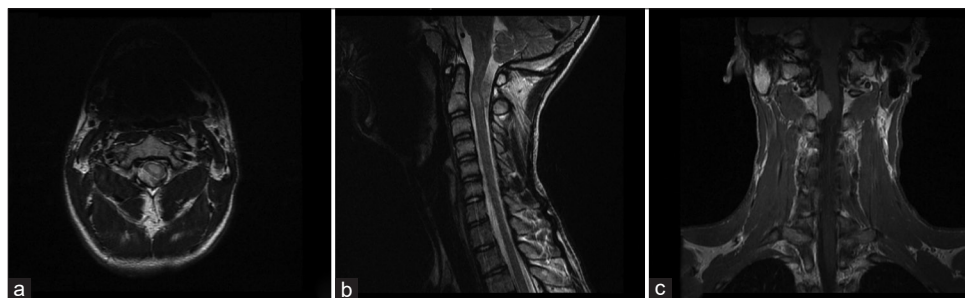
Preoperative magnetic resonance imaging (MRI) scans of Patient No. 1 with neurofibromatosis type 2: (a) Axial T2-weighted MRI with contrast shows a meningioma $23 \times 15 \times 8$ mm in size at the C1–2 level. The tumor adheres to the posterior-lateral side of the spinal canal. The meningioma presses and displaces the spinal cord. (b) Sagittal T2-weighted MRI with contrast shows the meningioma and coexisting intraspinal ependymoma sized $11 \times 9 \times 5$ mm at the C2 level. (c) Coronal T1-weighted MRI with contrast shows the meningioma before surgery.
